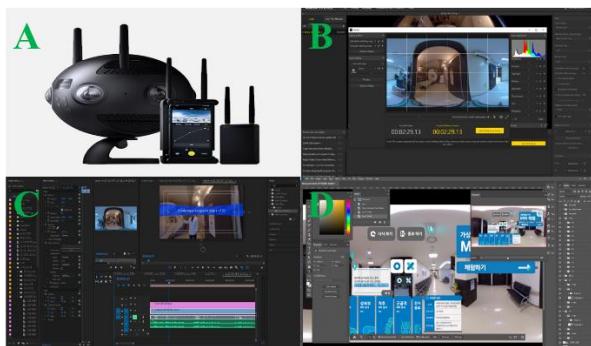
Shooting and editing to develop the VR MRI contents. A: Insta360 Pro2, B: Stitching the original sources, C: Stabilizer, D: Develop and insert 2D computer graphic sources
